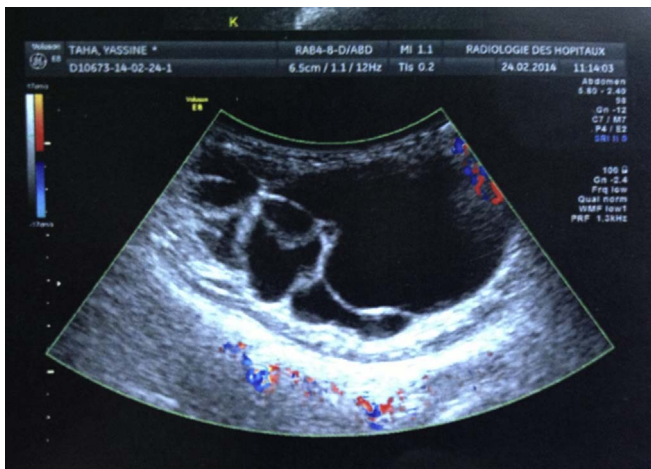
Ultrasound appearance of a superficial cystic formation, multi-partitioned, fluid content and well limited.
